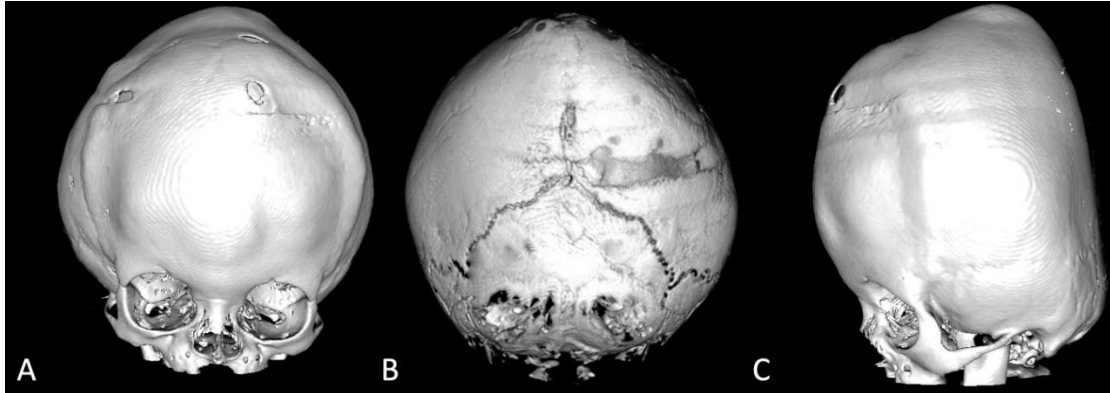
Preoperative Three Dimensional (3D) rendered CT-scan revealed multi suture craniosynostosis on axial (A), coronal (B) and sagittal view (C)
